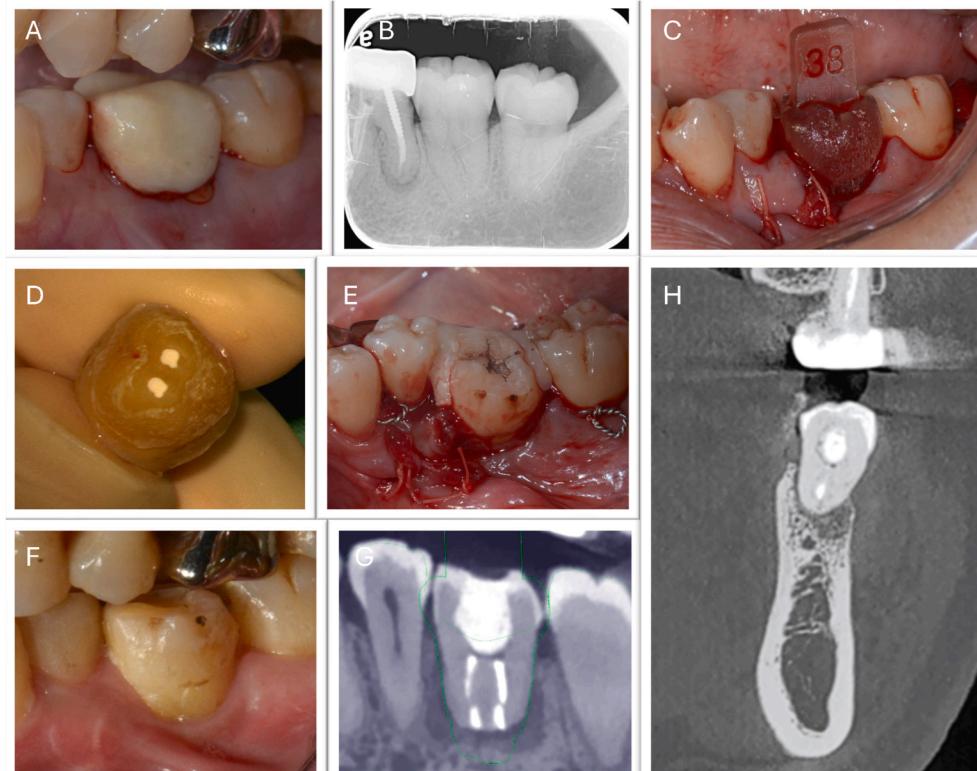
Clinical conditions of autotransplantation (AT). (A) Clinical photograph of tooth 36. (B) Periapical film of tooth 36 with a J-shaped radiolucency over distal apical region. (C) 3D-printed replica try-in. (D) Apicoectomy and retrograde filling with mineral trioxide aggregate (MTA) for the tooth 38. (E) Digital lingual stent fixation with wire and flowable resin. (F) Two-month post-operative clinical photograph of AT. (G) Two-month follow-up cone beam computed tomography (CBCT): superimposition of AT demonstrates precision of ideal position. (H) Two-month follow-up CBCT image showing bone remodeling after AT.
